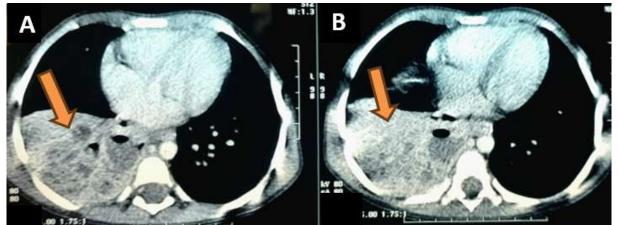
(A and B):-Axial chest CT scan sections showing a right basal pulmonary lesion with pre-abscess formation and atelectasis.
